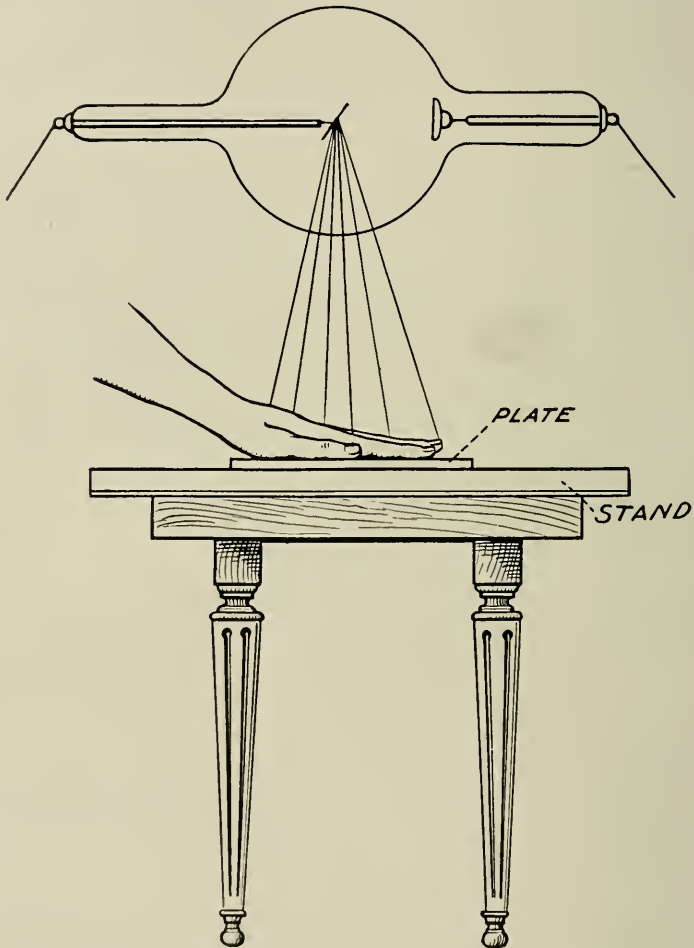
Showing relative positions of tube, hand, and plate for making a radiograph of the hand.
